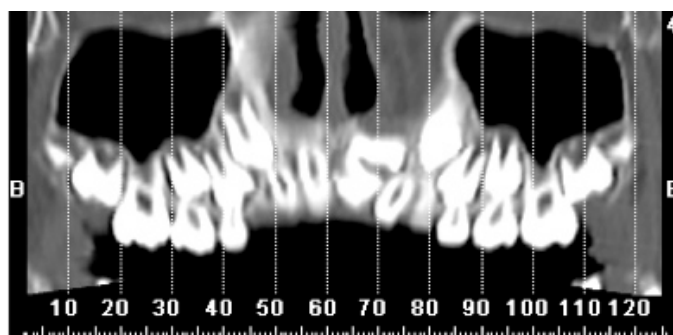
Panoramic image resulting of Dental CT evaluation. The patient's mixed dentition and impacted teeth are clearly shown.
